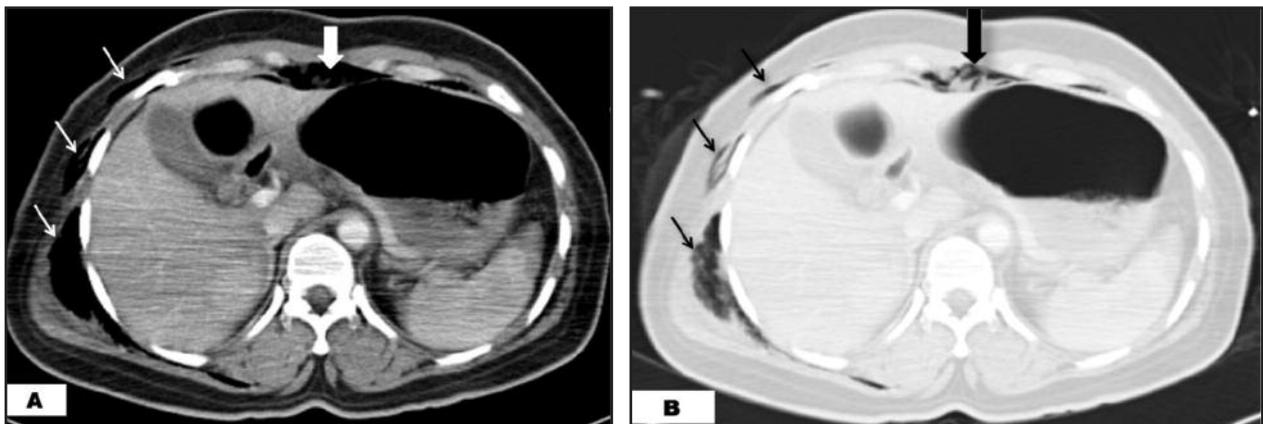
(A & B): Pseudopneumoperitoneum from extensive thoracic injuries. A 37 year old lady who sustained multiple and bilateral ribs fracture with flail chest and haemopneumothoraces following a road accident. Axial CT abdomen (A) soft tissue window and (B) lung window, showed air collection anterior to the stomach (broad arrow). Note the extensive subcutaneous emphysema (short arrow). She had no intra-abdominal injury and no haemoperitoneum.
